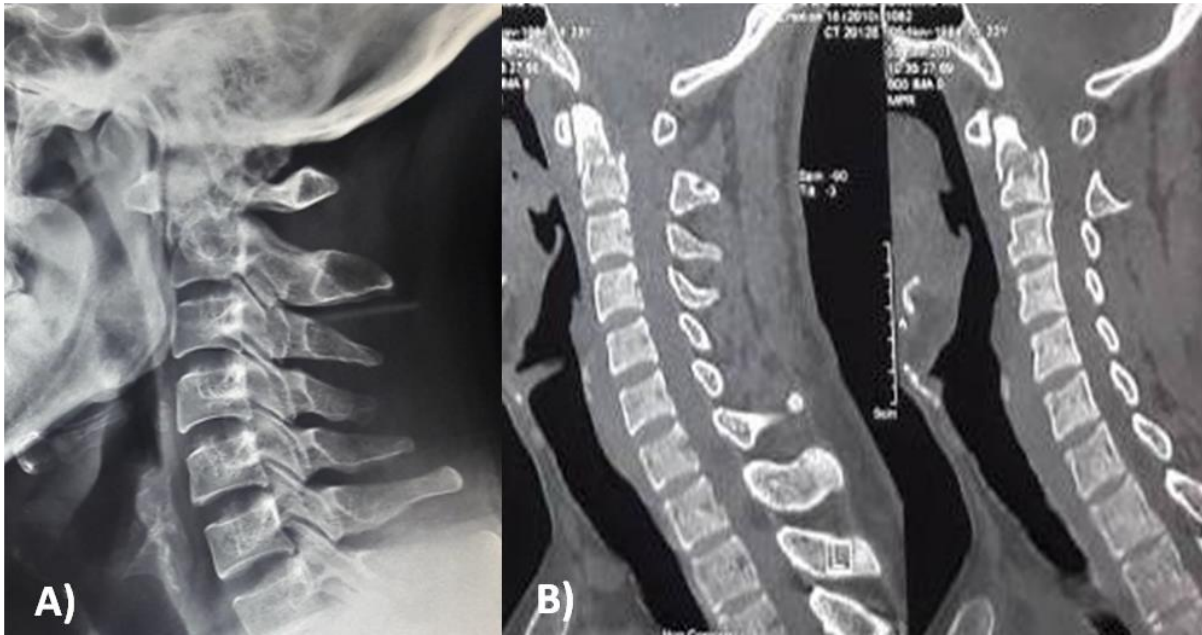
A) X-ray plain cervical spine, B) CT scan of cervical spine showing type II Odontoid fracture of case no. 1
